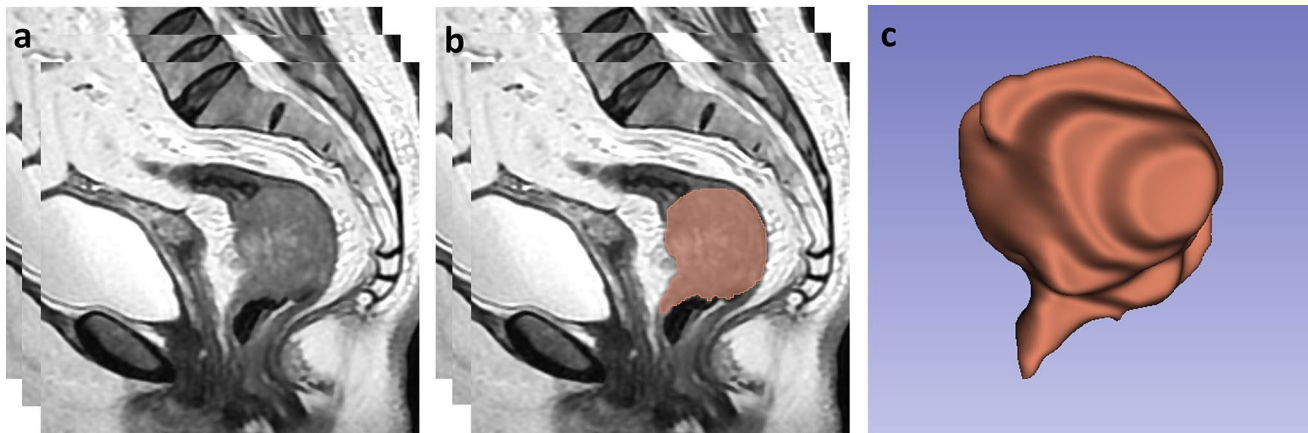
Segmentation technique. a sagittal T2W-MRI images of a patient with rectum cancer. b using all image slices in which the tumor appears, the segmentation is done manually along the whole
